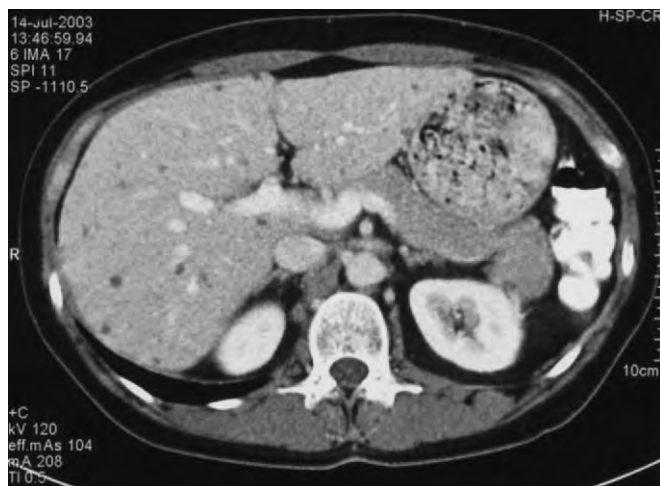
Contrast-enhanced CT scan of multiple biliary hamartomas (von Meyenburg complexes) evident as multiple cystic lesions.
